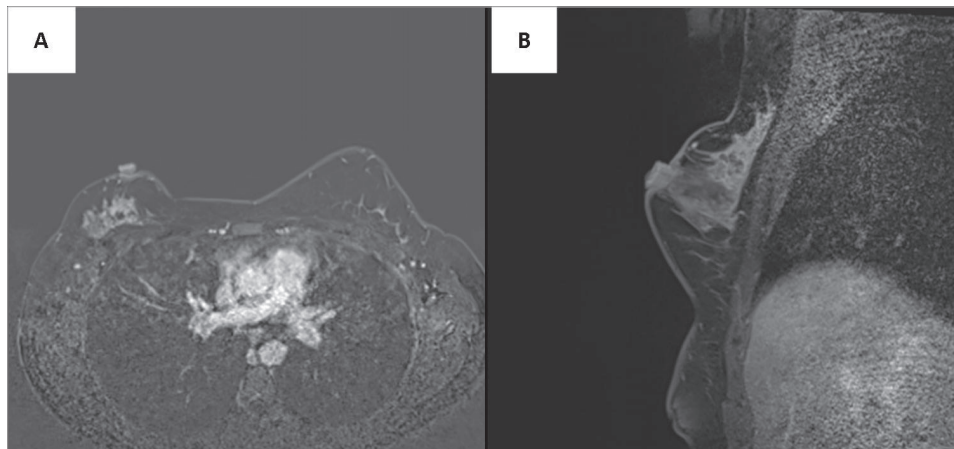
A. T1-weighted fat saturated axial MR image. B. T1-weighted post-contrast sagittal MR image - Peripheral enhancement at the lesion and adjacent non-mass segmental enhancements are observed.
